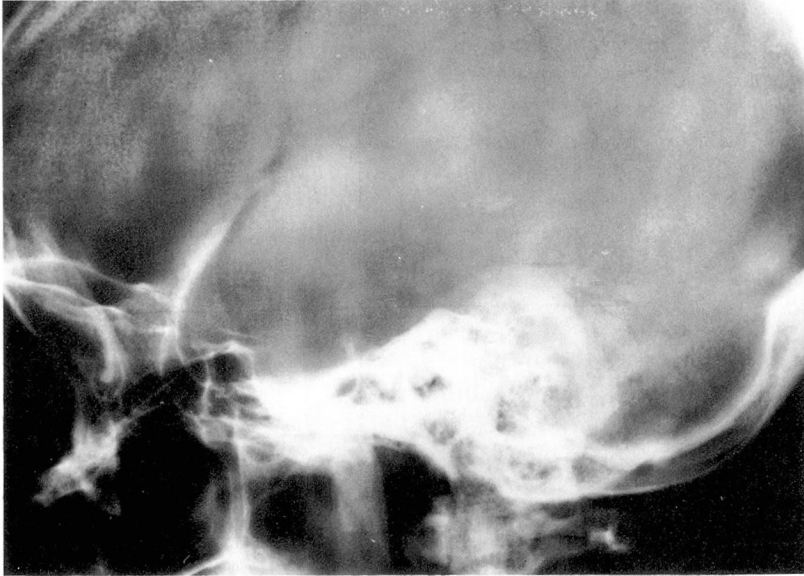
Lateral skull roentgenogram of patient.
